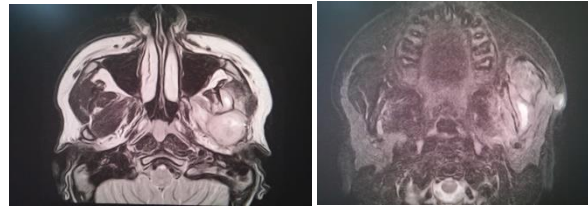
Pre-op MRI scan images.
